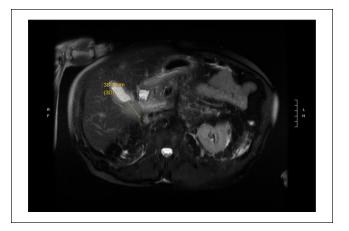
Magnetic resonance imaging the abdomen and pelvis with contrast showing an axial T-weighted image for a 3.8 cm mass that does not involve the cystic duct.
